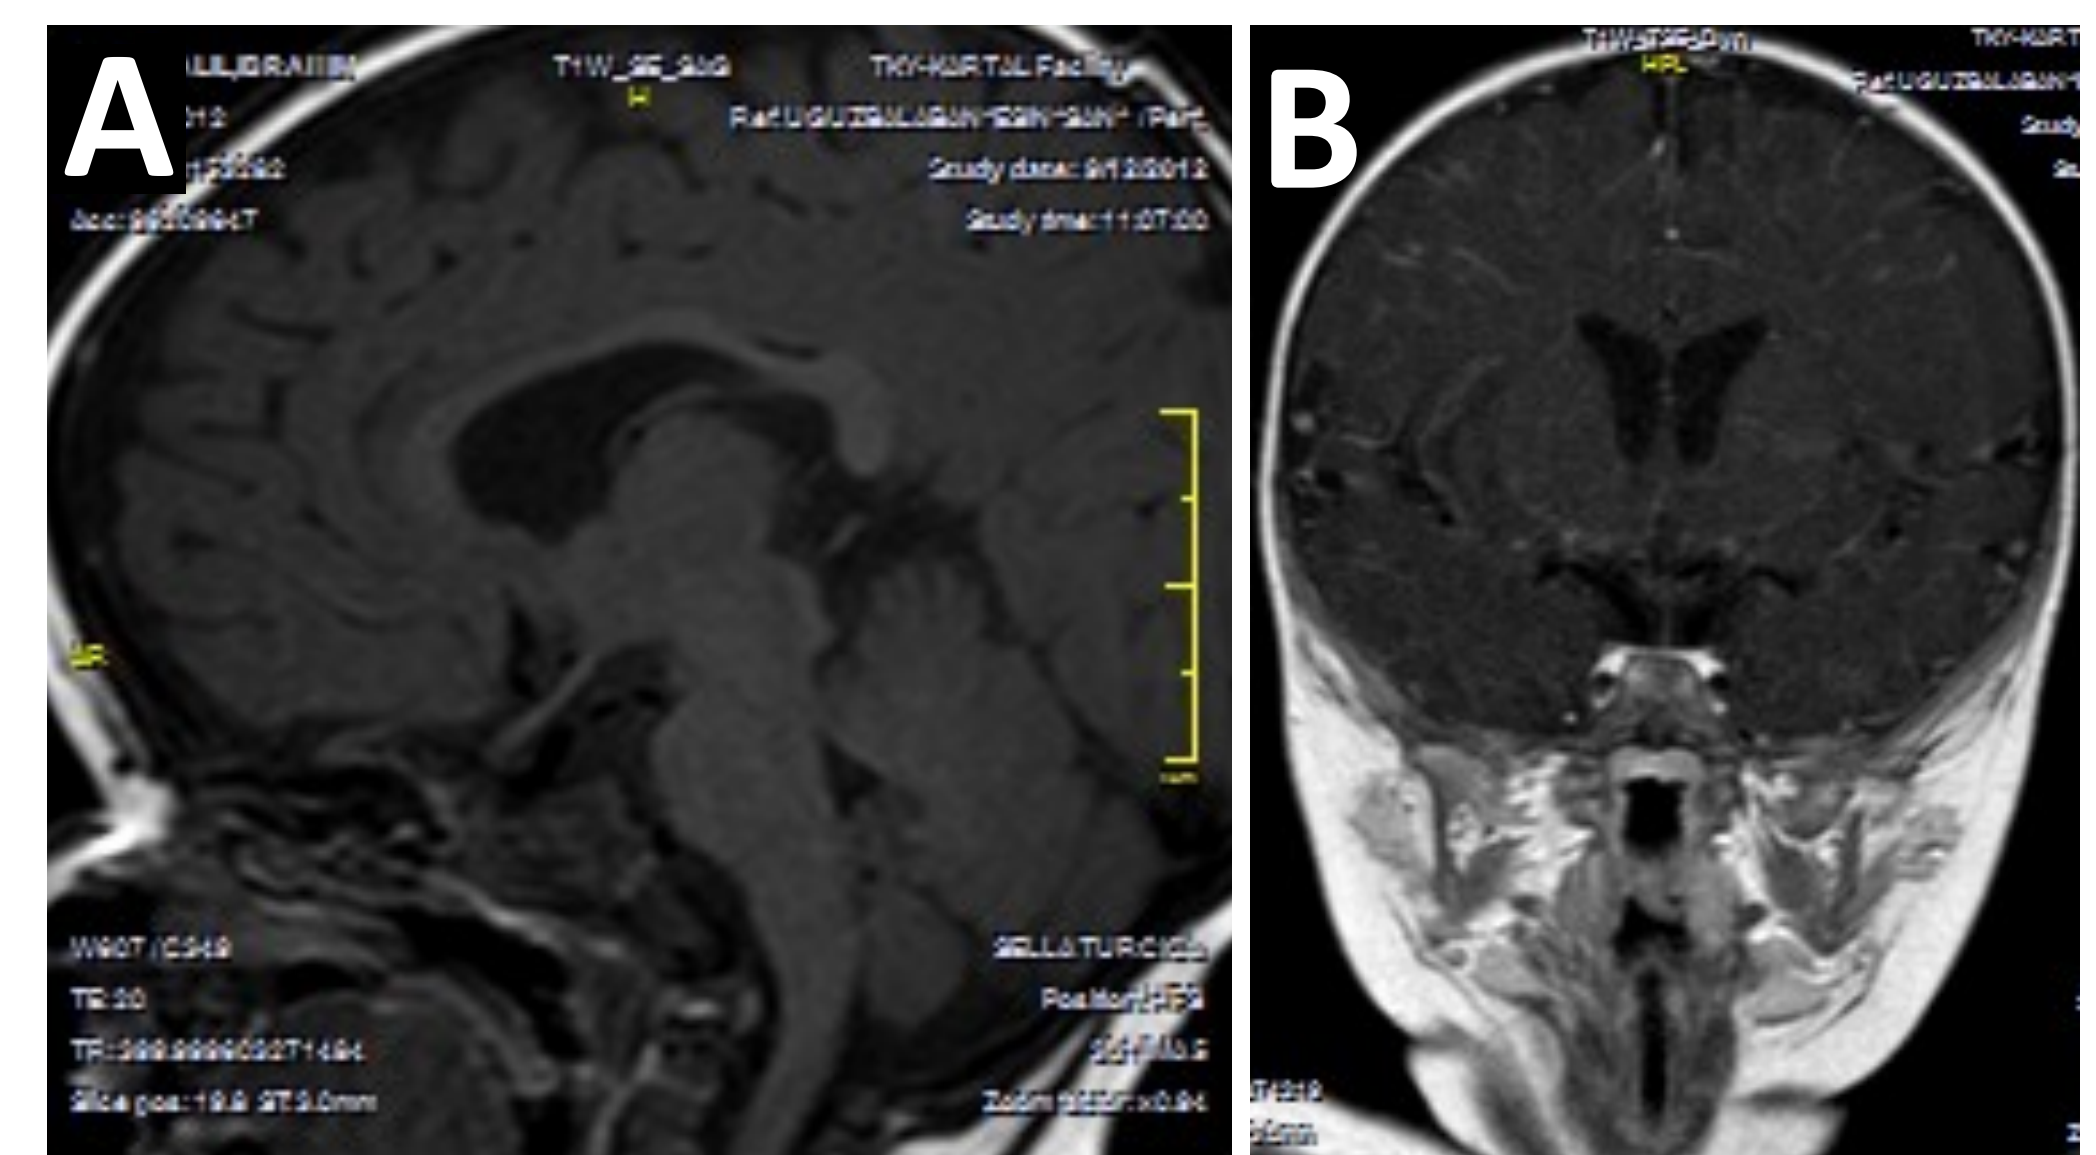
Sagittal (A) and coronal (B) T1 view of the MRI scan of the pituitary: the normal pituitary gland cannot be identified; anterior pituitary is hypoplastic, the sella turcica is shallow and poorly defined with no evidence of the normal high signal of the posterior pituitary.
